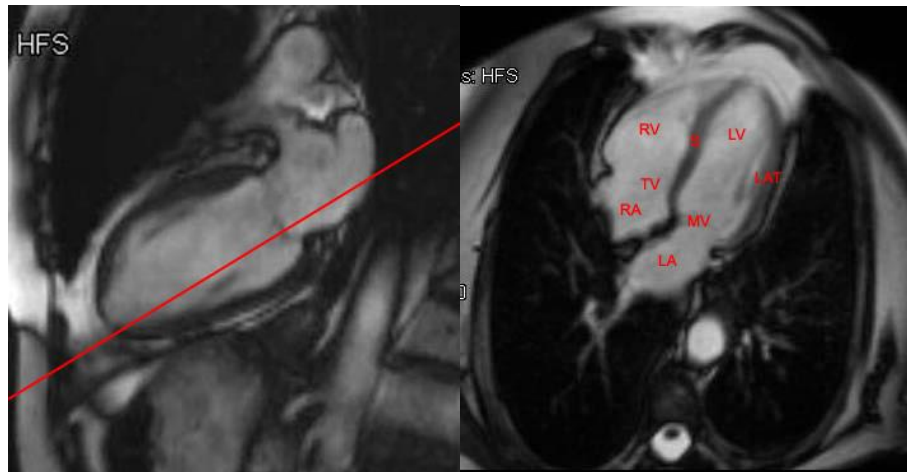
A horizontal long axis (four chamber view) of a cardiac MRI, the image on the right represents the plane obtained at the red line from the image on the left. LA = Left Atrium, LAT = Lateral wall, LV = Left Ventricle, MV = Mitral Valve, RA = Right Atrium, RV = Right Ventricle, S = Septum, TV = Tricuspid Valve
